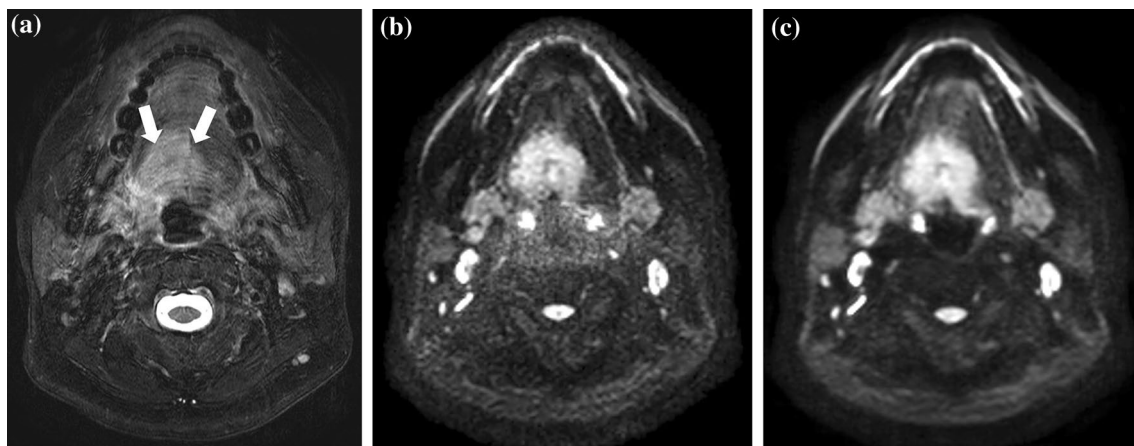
Representative patient with cancer at the base of the tongue. Fat-suppressed T2WI indicated the tumor lesion on the base of the tongue (a: arrow). In DWI with conventional PI-based reconstruction (b), overall image noise was noticeable throughout the image
